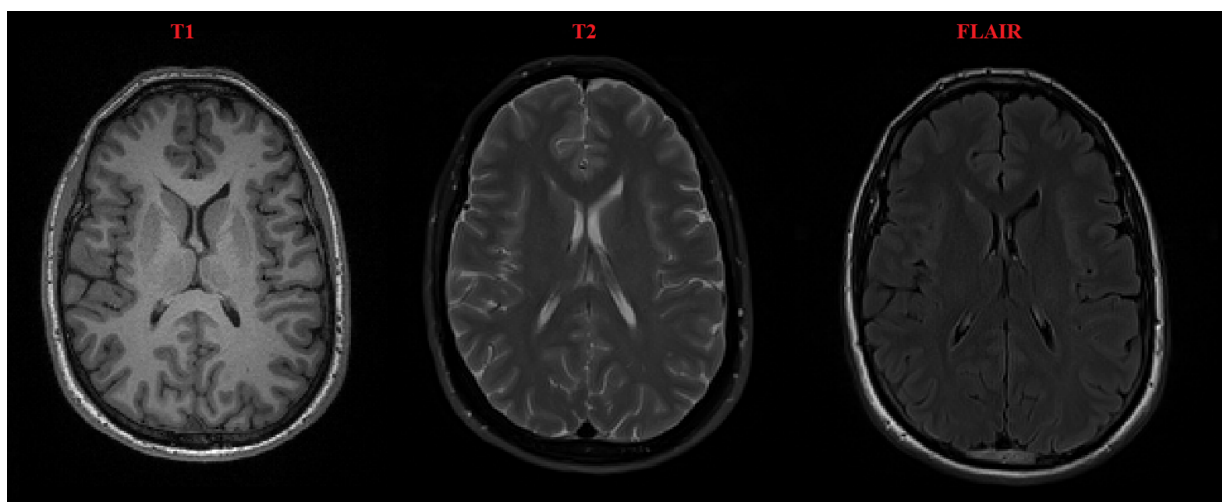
Examples of images recovered using T1, T2, and FLAIR sequencing.
